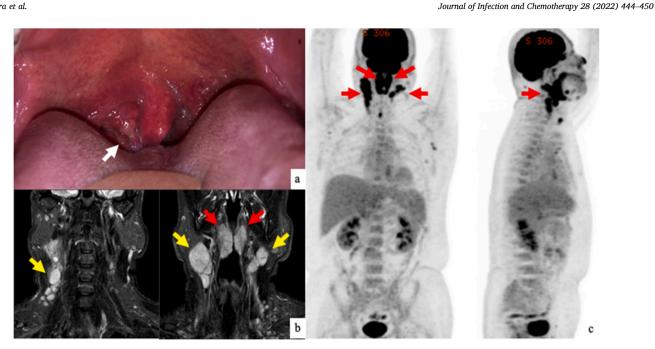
(Case 3): (a) A pharyngeal examination revealed bilaterally enlarged tonsils with a thin white mucous film on the right tonsil (arrow). (b) Magnetic resonance (MR) imaging of the neck at presentation showing bilaterally enlarged tonsils (red arrow) and bilateral cervical lymphadenopathy, particularly on the right side (yellow arrow). (c) Positron emission tomography/computed tomography (PET/CT) showing a high intensity signal on Waldeyer's ring and the cervical lymph nodes (red arrow).
